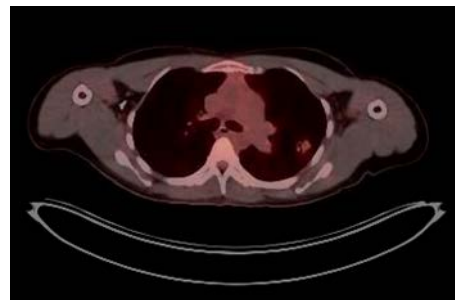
Chest PET CT, notable for left lung lesion
